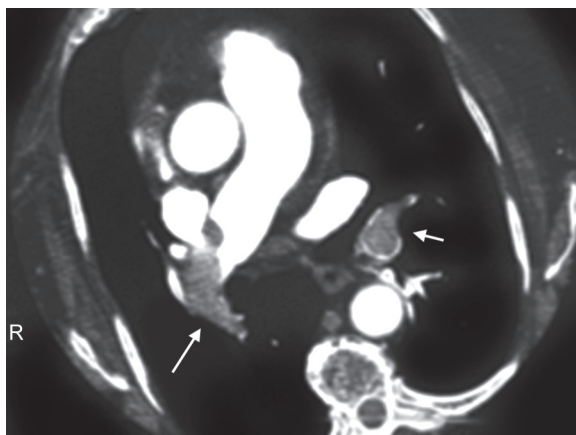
Computed tomography with intravenous contrast showing filling defects (emboli)
